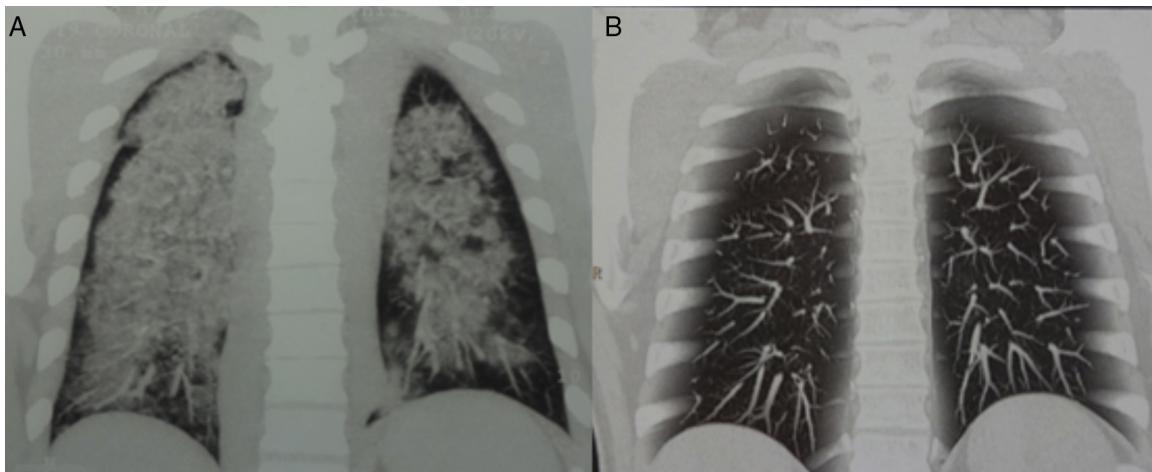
Chest CT coronal reconstruction of patient 1. (A) View prior to treatment, showing diffuse opacities compatible with diffuse alveolar hemorrhage and pulmonary capillaritis. (B) View after rituximab therapy, showing regression of lesions.
